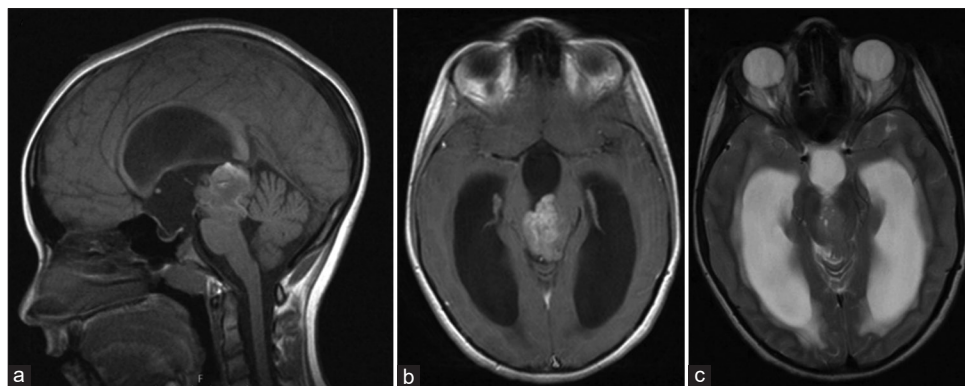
Preoperative magnetic resonance imaging (MRI). T1 contrast-enhanced midsagittal MRI displays a tumor mass located in the pineal region, demonstrating heterogeneous post contrast opacification, signs of hemorrhage, and cystic areas (a and b). T2-weighted axial MRI reveals tumor hypercellularity, a ballooned third ventricle and enlarged lateral ventricles-signs of hydrocephalus (c).
